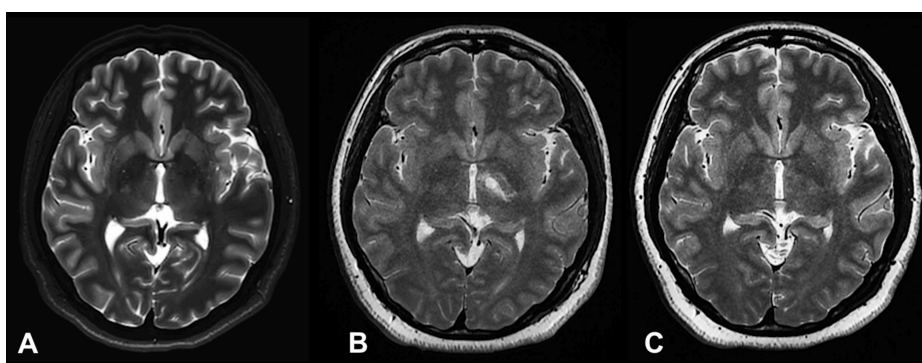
MR-guided focused ultrasound ablation of the left pallidothalamic tract (mirror-based targeting).
